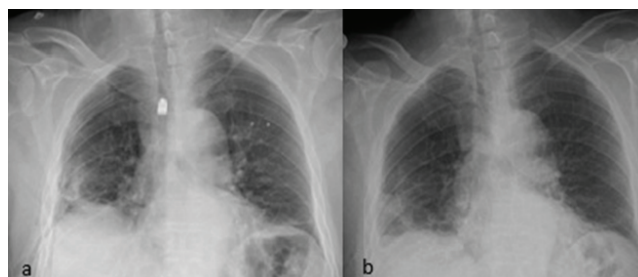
Chest radiograph on postoperative day 1 (a), chest radiograph obtained before hospital discharge (b).
